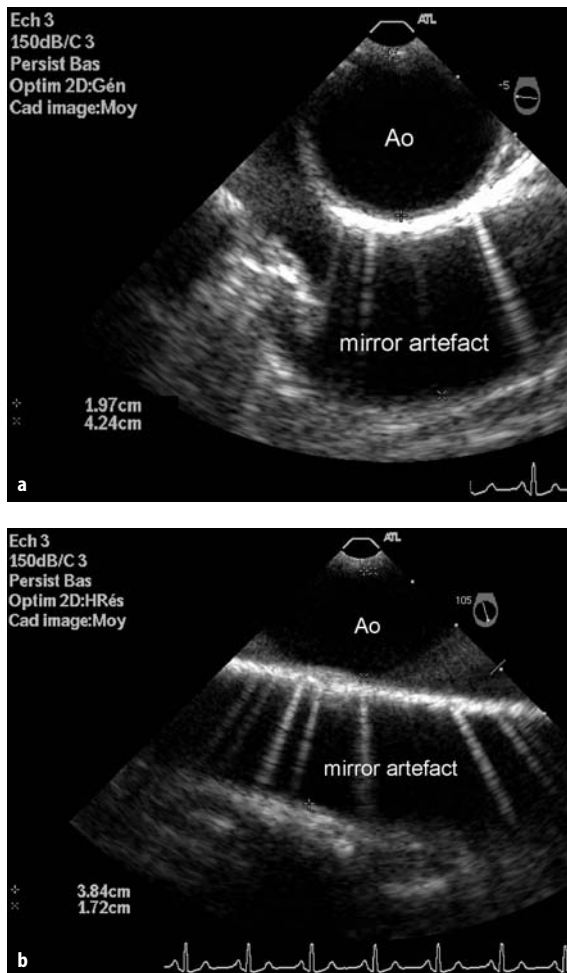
Transesophageal artefacts of aortic dissection. Mirror artefact in descending aorta mimicking two channels. a Transverse view. b Longitudinal view. Ao aorta
